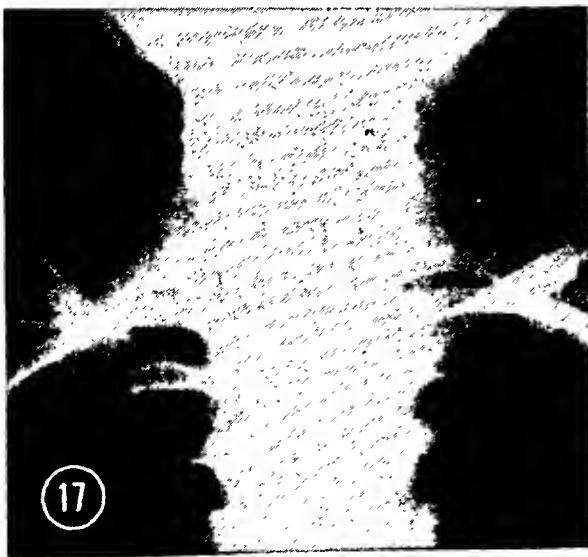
is just one example of a complicated staple case. This man was fixing a fence and had his mouth full of staples and nails when somebody told him a funny story. He got one staple in each bronchus and a nail in the right lower lobe. They were all removed by fluoroscopic guidance. Incidentally he did not realize that he had swallowed the objects until some days after the accident. He went to the doctor a week or so later and said he had a bad cough. I think he mentioned the incident, and the doctor had the x-ray taken, which gave the explanation.
